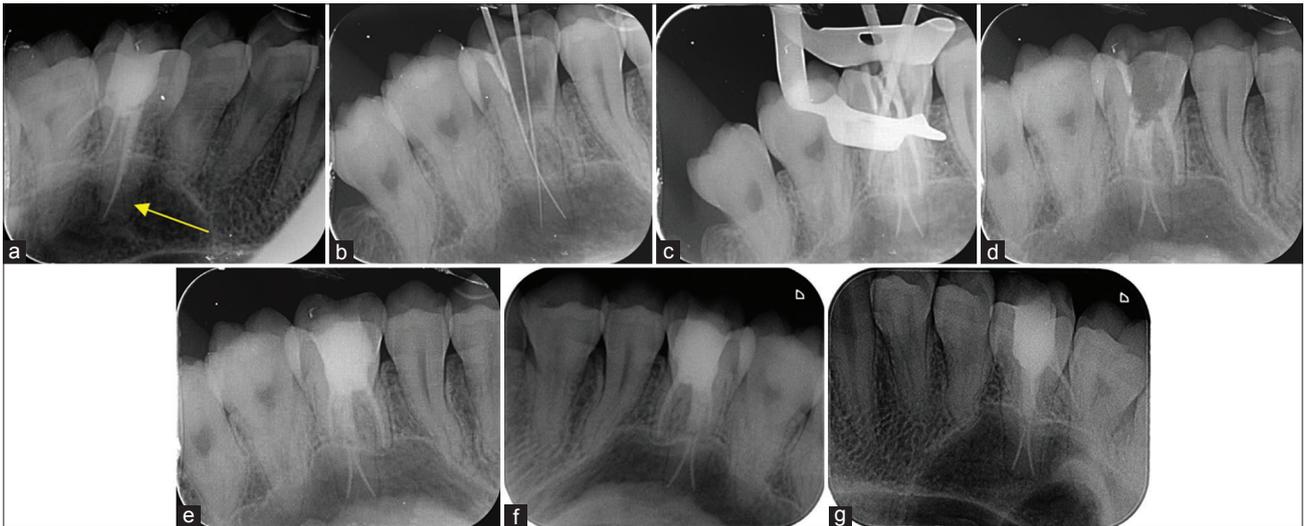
(a) Pre-operative radiograph showing missed canal at apical third level of the root. (b): Working length radiograph of palatal canals, (c): Master cone radiograph, (d): Post-obturation radiograph, (e): Post-endodontic restoration, (f): Six months follow-up, (g): One year follow-up
